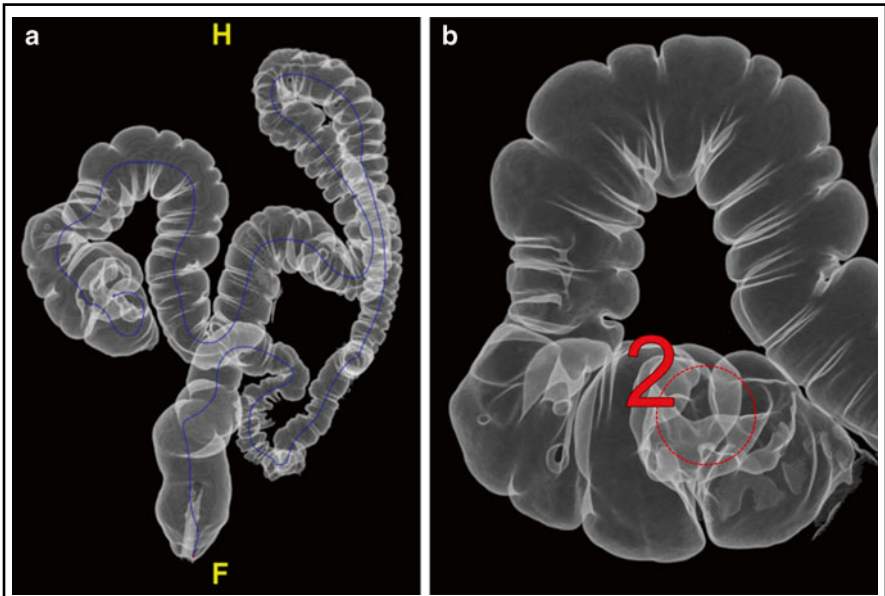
CT COLONOGRAPHY
